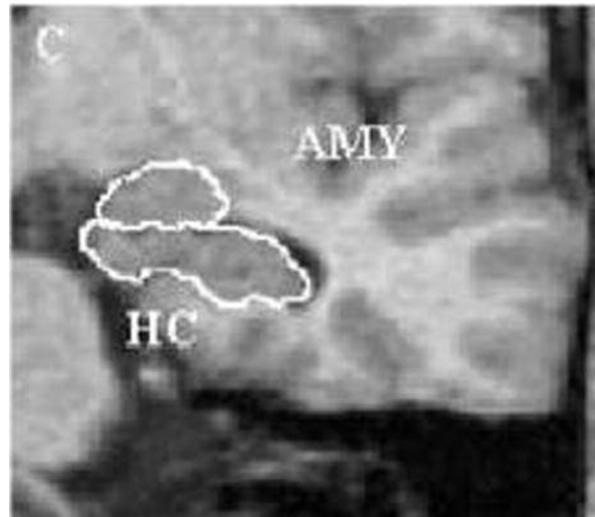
Manually traced boundaries of the amygdala (AMY) and the hippocampus (HC) on coronal magnetic resonance images in patient with Down syndrome
